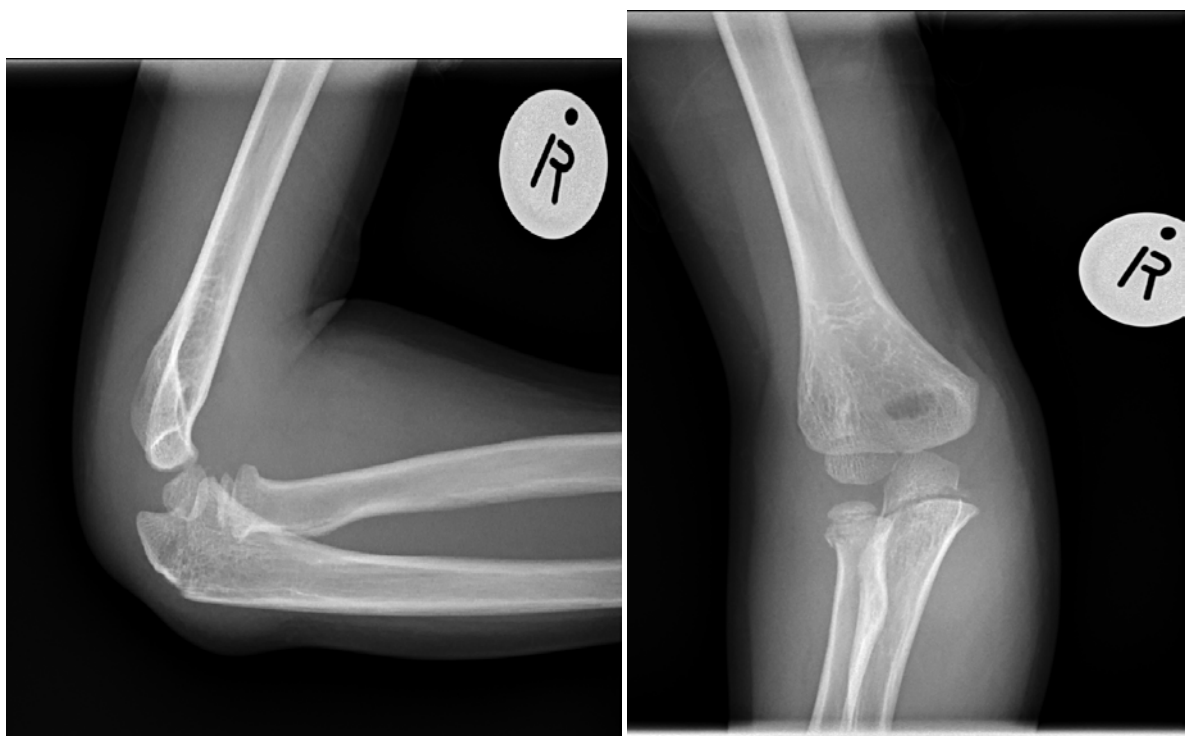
Lateral and AP radiograph of slide 18 (pre-tutorial) and slide 9 (post tutorial)
